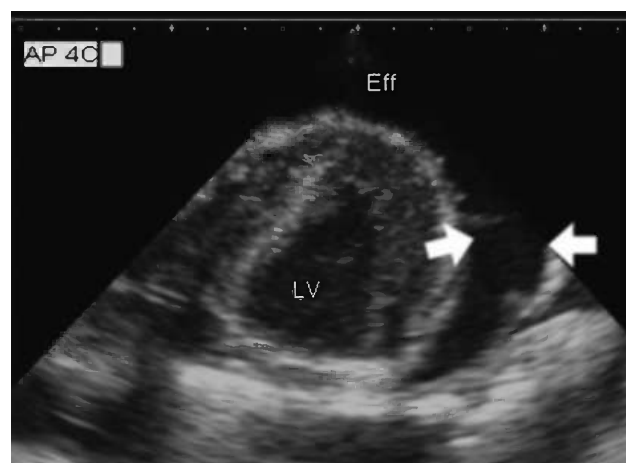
Apical four-chamber view. Eff, effusion; LV, left ventricle.
